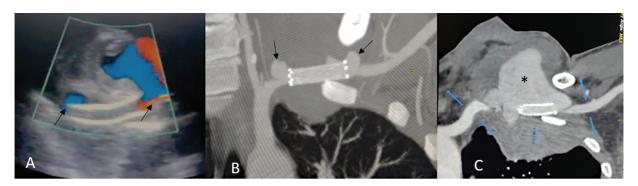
(A) Color Doppler and (B) computed tomography (CT) angiography coronal images, 15 days after the procedure showing active color Doppler flow and contrast filled extravasation at the proximal and distal ends of stent (*black arrows*). (C) CT angiography done 45 days after the initial procedure shows frankly ruptured partially thrombosed recurrent pseudoaneurysm (*).
